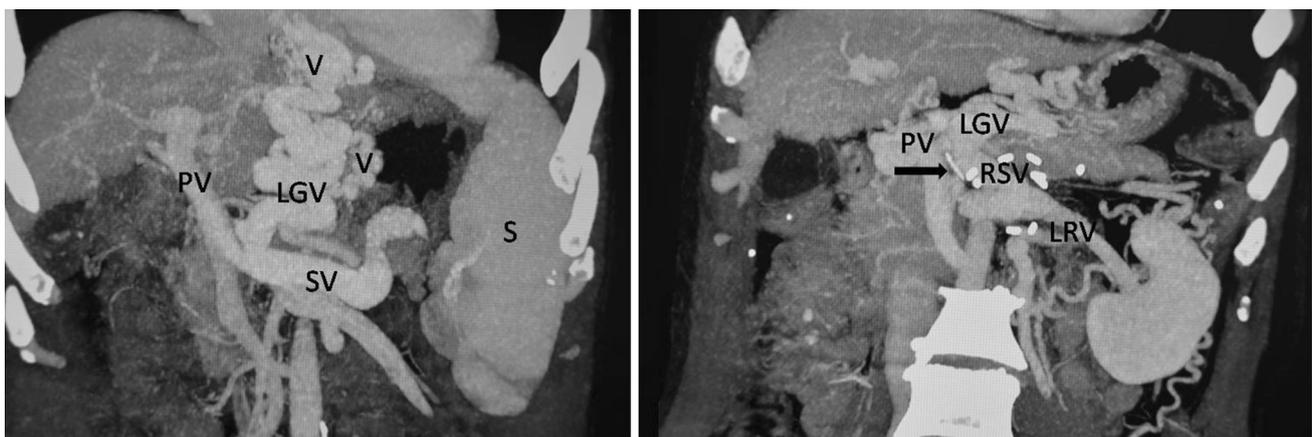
Comparison of a patient's preoperative (left) and postoperative (right) computed tomographic portal venograms (V, varices; S, spleen; PV, portal vein; LGV, left gastric vein; SV, splenic vein; RSV, remnant splenic vein; LRV, left renal vein. Clip indicated by arrow)
